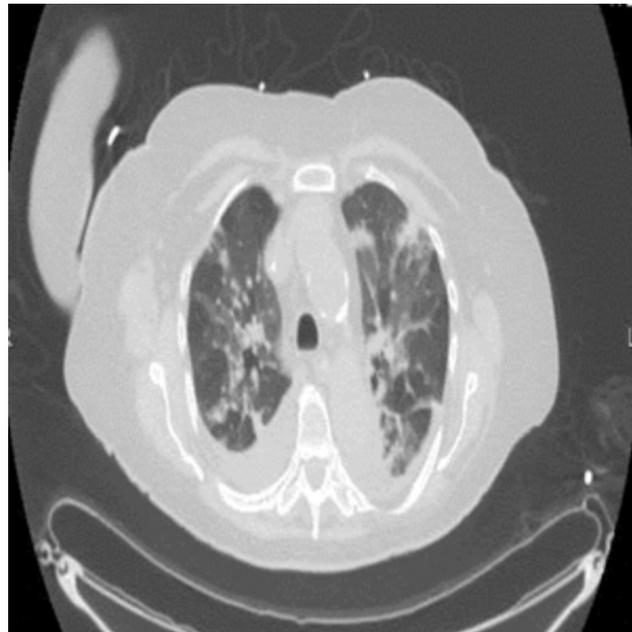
CT of chest showing bilateral pulmonary infiltrates and consolidations indicative of bilateral pneumonia.
